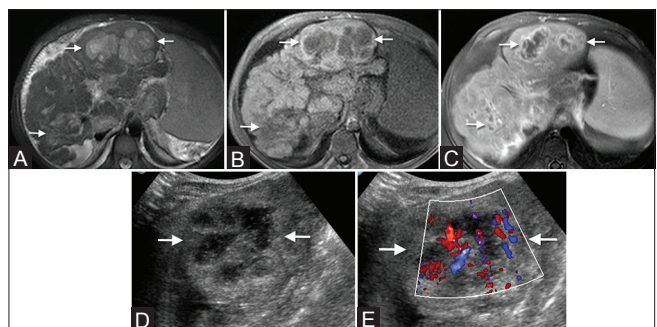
(A-E): Hepatic infarcts. Axial T2W fat saturated (A) axial T1W (B) and post-contrast T1W fat saturated (C) images show multiple lobulated lesions that are predominantly central in location adjacent to portal tracts (arrows). These areas show high signal on T2W (A) low signal on T1W (B) and show smooth peripheral enhancement (C). Gray scale (D) and color (E) ultrasound images show these areas as hypoechoic areas with increased vascularity surrounding them. These infarcts are pathologically confirmed on explanted liver
